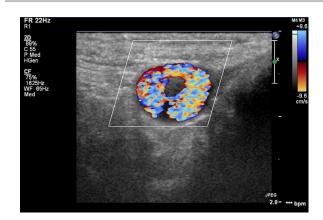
Access planning ultrasound. Color Doppler ultrasound image of the left common femoral artery in transverse view demonstrates marked "corkscrew" tortuosity.
